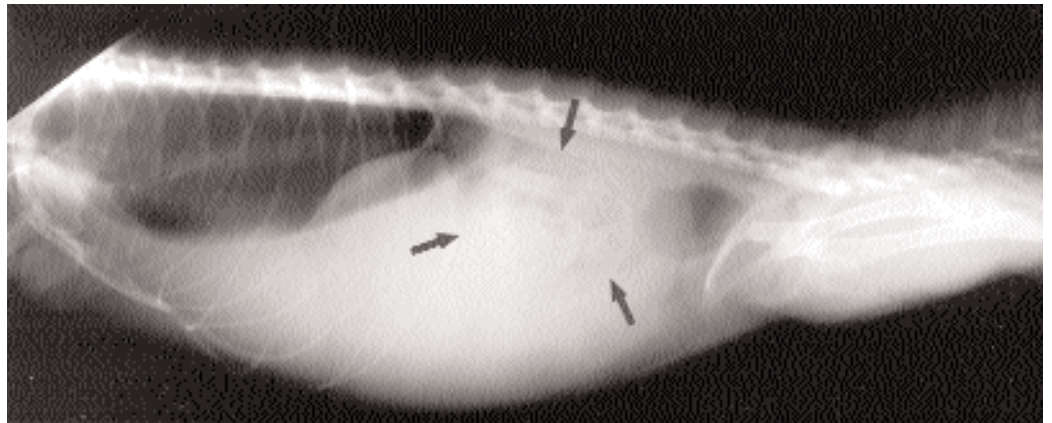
The same radiograph as in Figure 3. Note the mottled gas and soft tissue density pattern in the dorsal mid-coelomic region (arrows).
